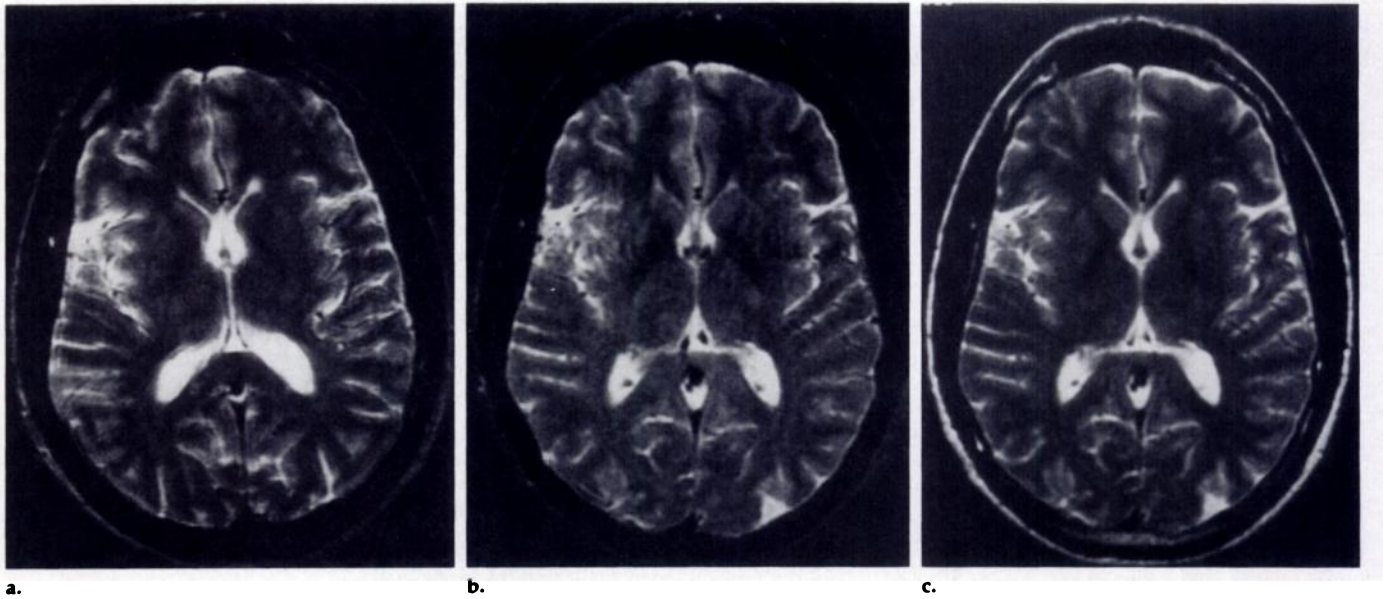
Comparison of tissue contrast in (a) GRASE, (b) spin-echo, and (c) RARE MR images of the brain. The three multisection images were acquired with a TR of 2.5 seconds and a section thickness of 5 mm. (a) The GRASE image was obtained with NSA = 2 and an image time of 45 seconds for 13 sections. (b) The spin-echo image was obtained with conjugate synthesis (NSA = 1/2) and an image time of 4.6 minutes for 25 sections of both proton-density and T2-weighted images. (c) The hybrid RARE image was obtained with NSA = 2 and an image time of 64 seconds for 13 sections. RARE and spin-echo images were acquired with a TE of 100 msec, while the GRASE TE differed slightly (104 msec) due to sequence timing differences.
